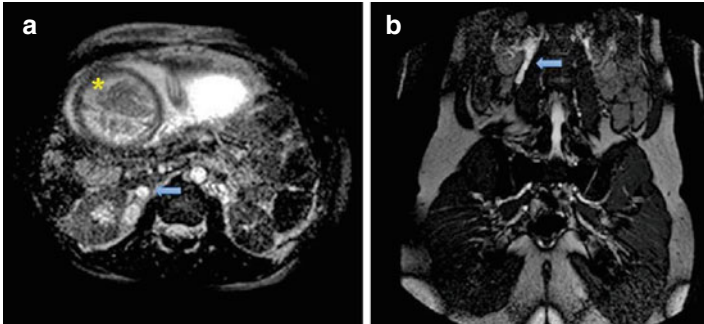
MRI sequence shows a right hydroureteronephrosis with a regular left kidney in a 30 weeks pregnancy woman. (a) T2 weight axial sequence (*blue arrow* shows right ureter dilatation, \* shows fetal head). (b) T2 weight coronal sequence (Courtesy of Dr.ssa Federica Fiocchi, University of Modena and Reggio Emilia, Policlinico di Modena)
